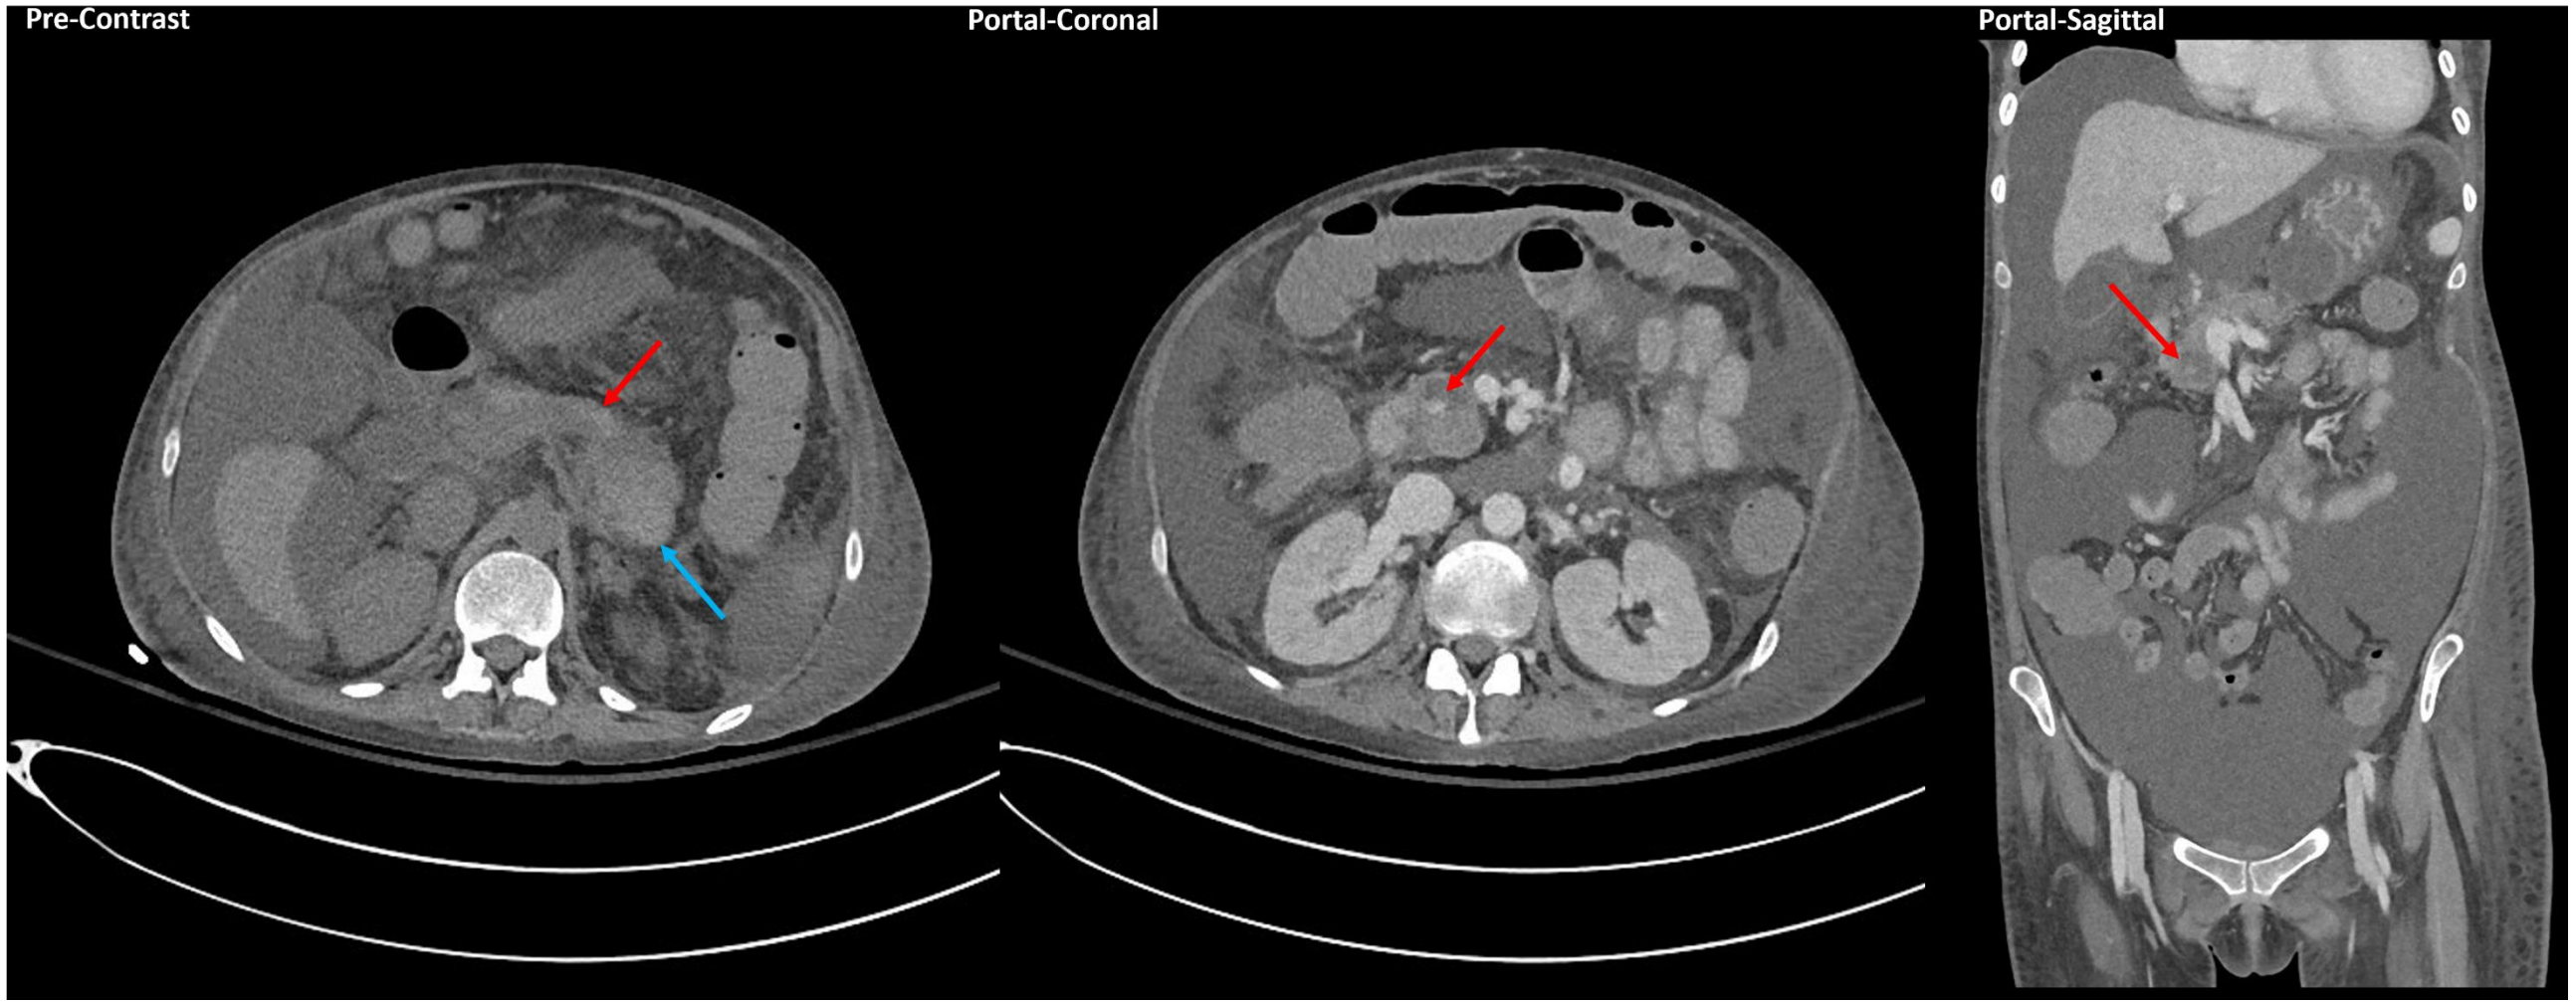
CT angiography series showing contrast in the duodenal lumen at the level of the ampulla consistent with hemorrhage via the pancreatic duct.
